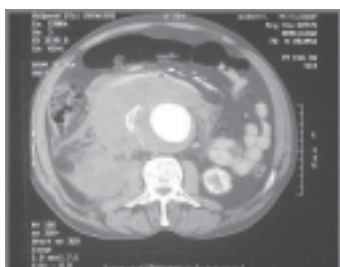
CT scan showing aneurysmal aorta with indistinct anterior margin and extravasation of blood into the surrounding areas suggestive of contained rupture
